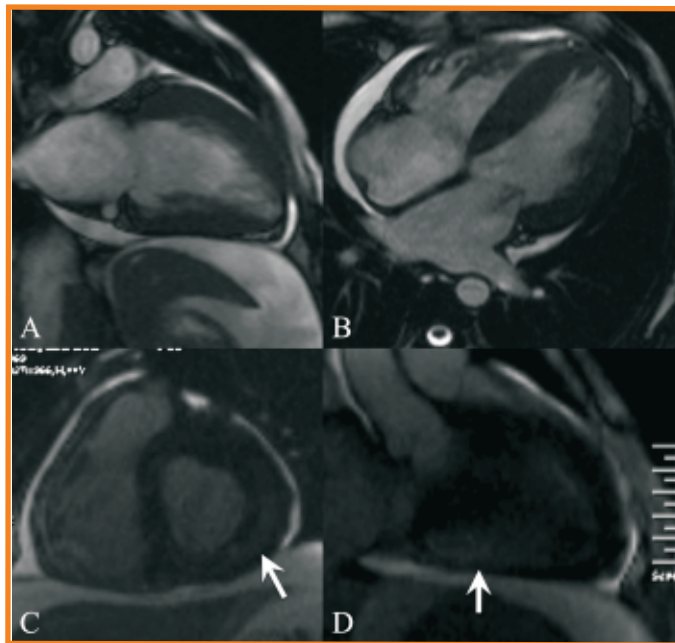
(A-D): Suspected storage disorder. This lady presented with arrhythmias. The cardiac MRI shows thickening of the walls of all the chambers seen in the 2-chamber (A) and 4-chamber (B) views. The delayed contrast-enhanced images in the short axis (C) and 2-chamber (D) views show abnormal mid-myocardial enhancement (arrows) involving mainly the basal and mid infero-lateral segments. This pattern of enhancement has been described in Alexander-Fabry disease and other similar storage disorders of the heart. She then gave a history of similar complaints and early deaths of her father and grandfather, confirming a congenital/genetic etiology. She is being further investigated for the exact etiology of her cardiomyopathy.
